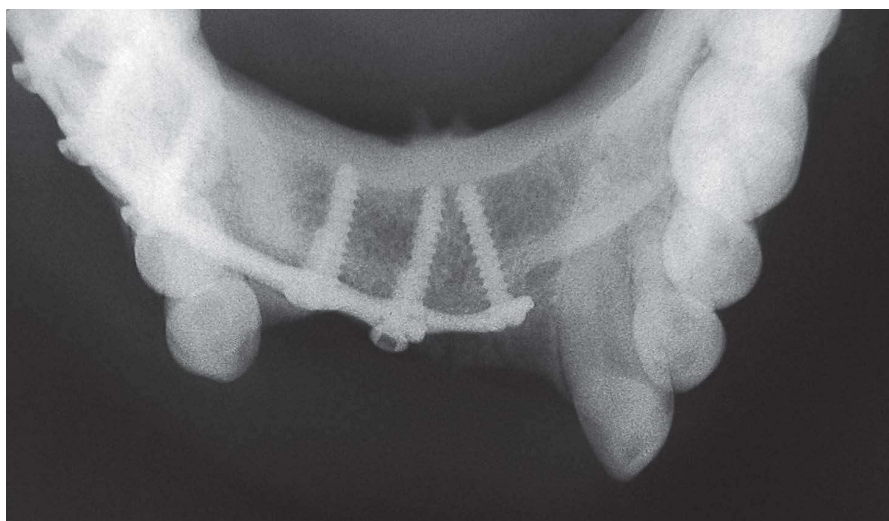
Initial radiograph.
